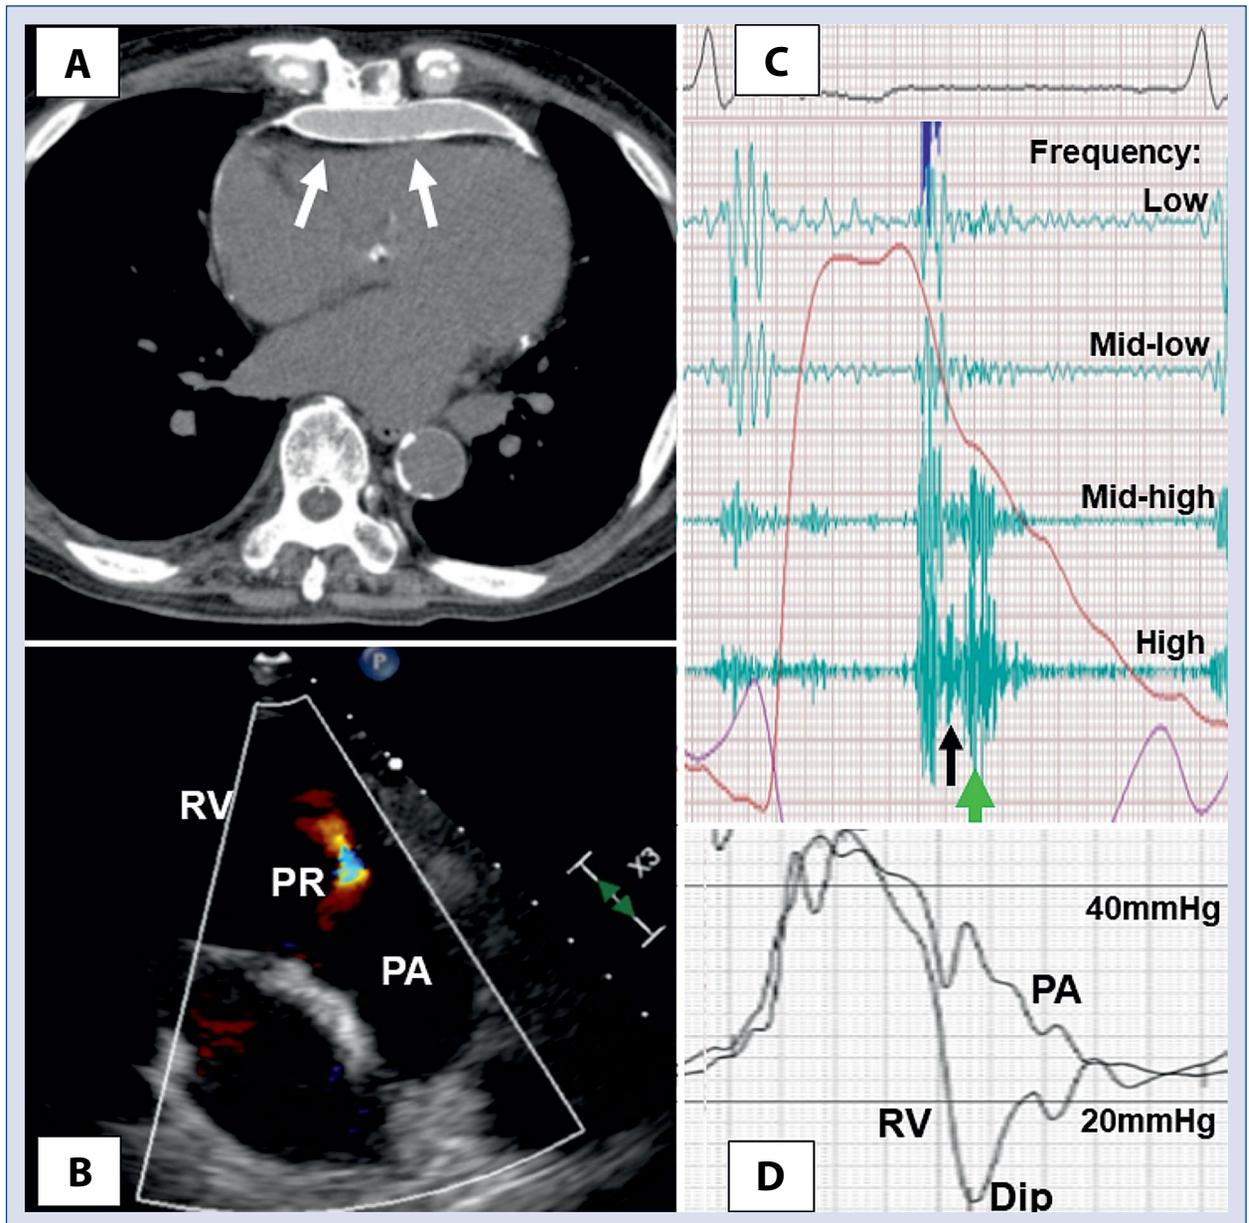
A. A calcified pericardial layer in the computed tomography (white arrows); B. Moderate pulmonary regurgitation (PR) in echocardiography; C. A high-pitched murmur (green arrow) during early diastole right after the pulmonary component (black arrow) of the second heart sound in a phonocardiogram recorded at the left sternal border; D. The gradient with rapid deceleration between pulmonary artery (PA) pressure and the dip of the right ventricular (RV) pressure recorded at catheterization.
